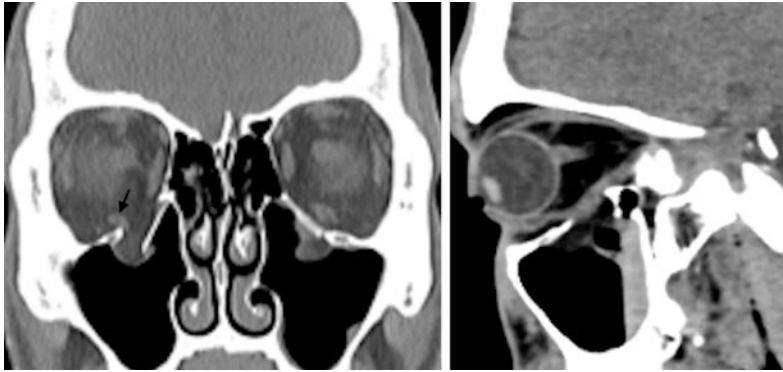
Blow out fracture of the inferior orbital wall. a, b Coronal and sagittal reformatted CT images demonstrate fracture of right orbital floor with inferior displacement of the fracture segment and entrapment of the inferior rectus muscle (arrow)
